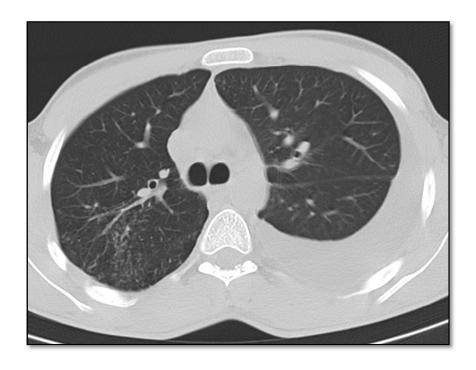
CT plain axial section showing moderate right sided pleural effusion with associated tree-in bud pattern in patient with tuberculosis
